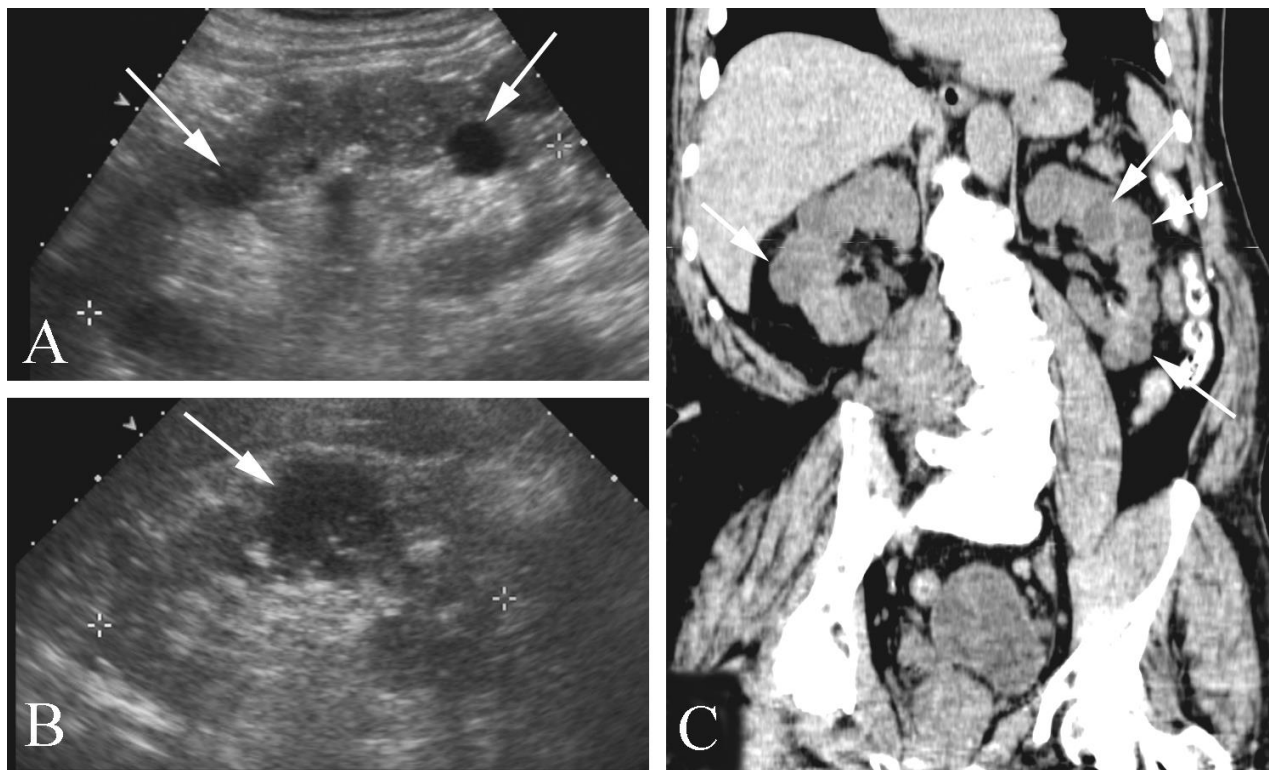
Polycystic kidney disease in a 63 year old with hematuria. A. Ultrasound study of the left kidney shows two cysts (arrows). B. Ultrasound study of the right kidney shows an additional cyst (arrow). C. Coronal reformatted image from a CT-KUB shows multiple variably sized cysts (arrows).
